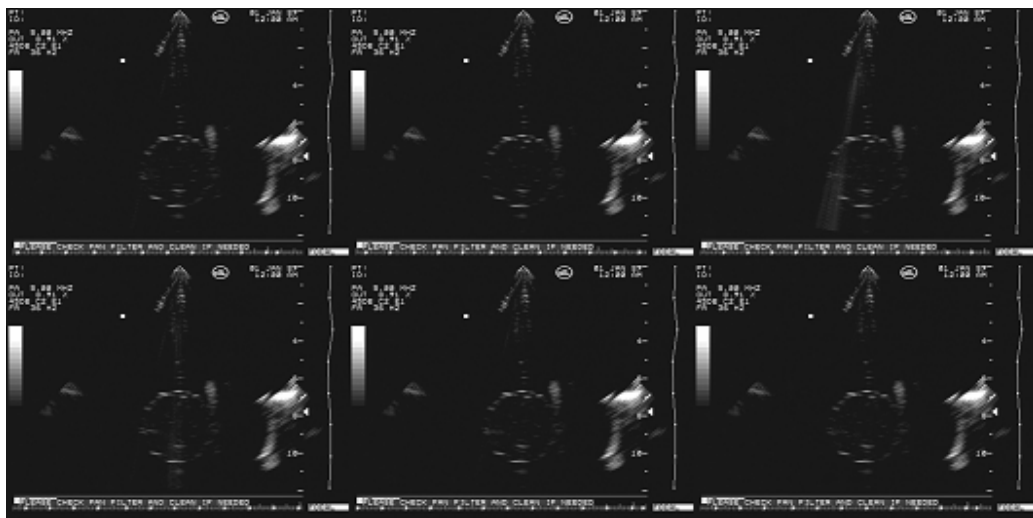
PLA microbubbles excited by an ultrasonic pulse of 250 mVpp.
